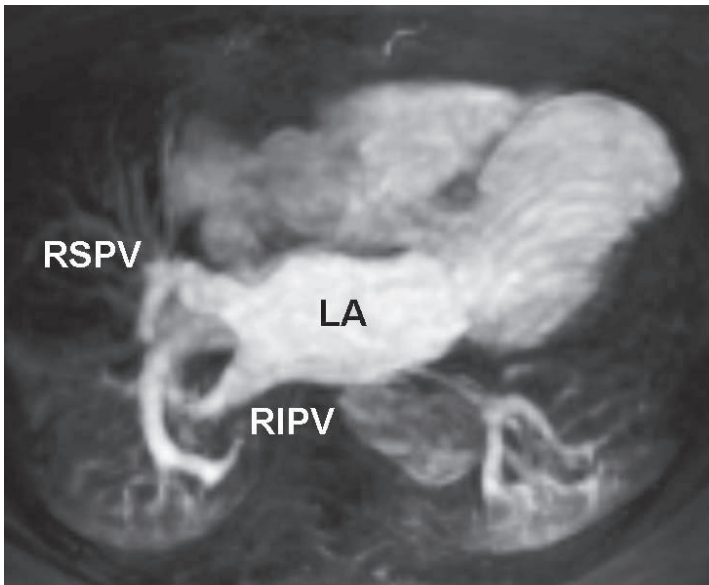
Maximum intensity projection of a gadolinium enhanced MRI angiogram of the pulmonary veins. LA = left atrium; RIPV = right inferior pulmonary vein; RSPV = right superior pulmonary vein
